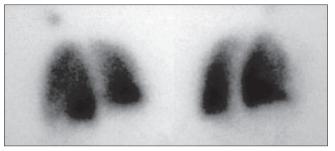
Ventilation-perfusion scintigraphy of the patient n°2 several bilateral segmental perfusion defects
